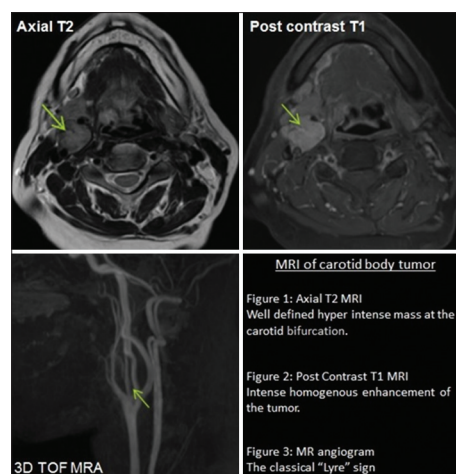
Magnetic resonance imaging of carotid body tumor
